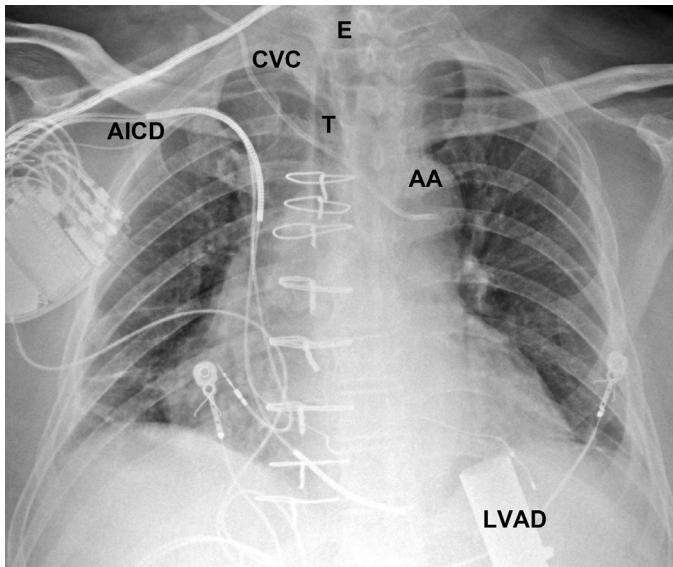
■ Anteroposterior (AP) supine chest x-ray. Central line (CVC) that was placed in the right internal carotid artery instead of the right internal jugular vein. Instead of traveling straight downward along the right paramediastinum, the CVC courses obliquely across the superior mediastinum to the aortic arch (AA). AICD, automatic implantable cardioverter defibrillator; E, esophagus; LVAD, left ventricular assist device; T, trachea.
